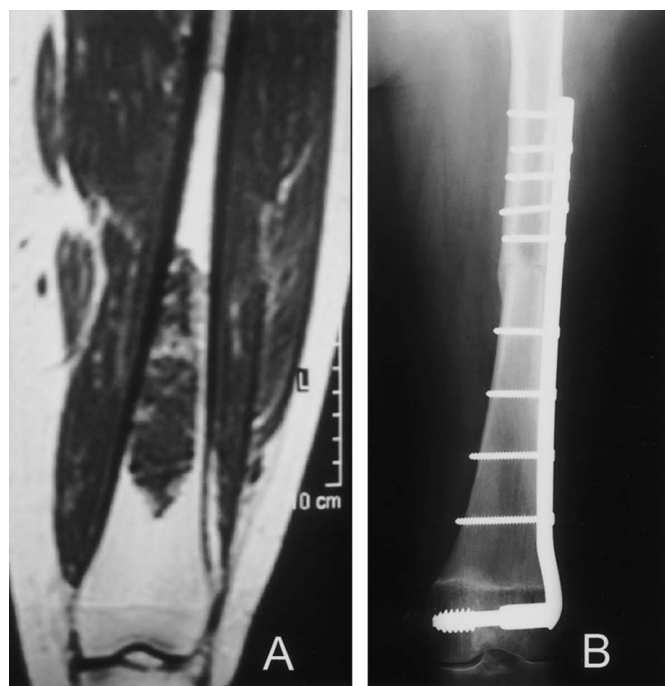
Imaging studies show a metaphyseal intercalary segmental allograft of the distal femur fixed with plate and screws, in a 48-year-old woman who had a resection of a chondrosarcoma. (A) A coronal T1-weighted MRI scan shows the femoral lesion extension. (B) An anteroposterior radiograph of the distal femur intercalary segmental allograft reconstruction fixed with a dynamic condylar screw, obtained at 3 years followup, shows healing of diaphyseal and metaphyseal host-graft junctions.
